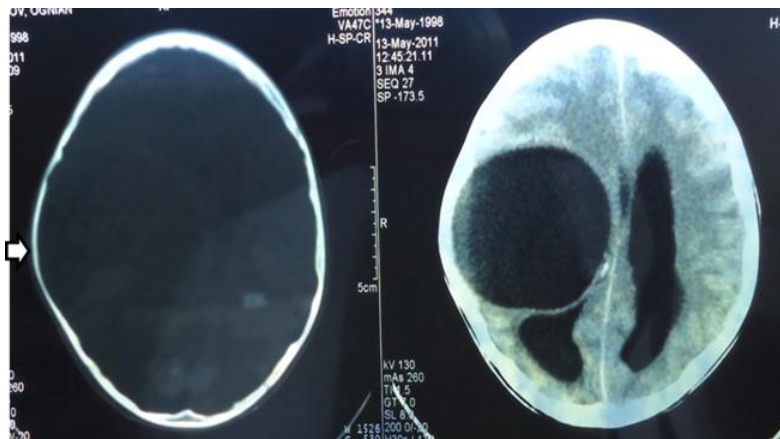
CT image of cerebral echinococcosis in the parietal region, causing thinning and deformation of the overlying bone
